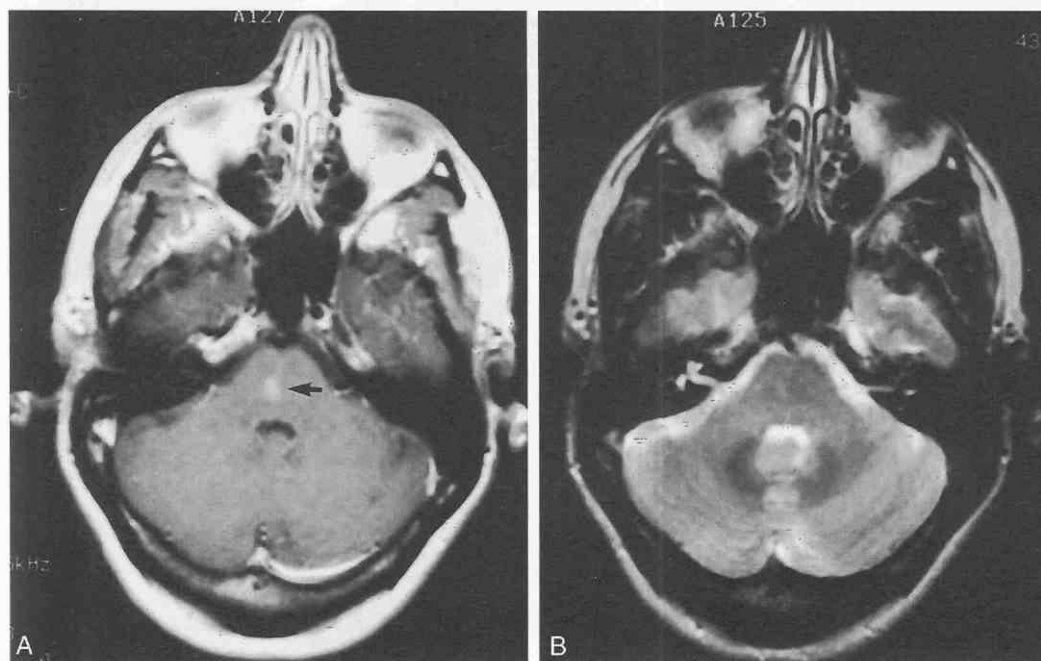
Contrast-enhanced T1-weighted MRI examination (A) demonstrating a pontine capillary telangiectasia (arrow) that is not well visualized on the T2-weighted study (B).
